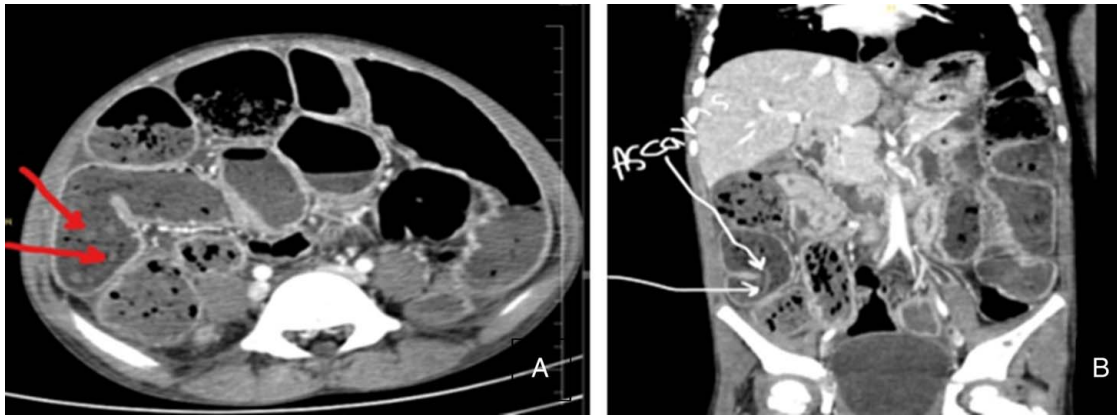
(A and B) Contrast material-enhanced computed tomography scans of the abdomen demonstrate multiple dilated, fluid-filled and gas-filled loops of small bowel. Multiple curvilinear structures, most of which are gas filled, are seen within the bowel.
